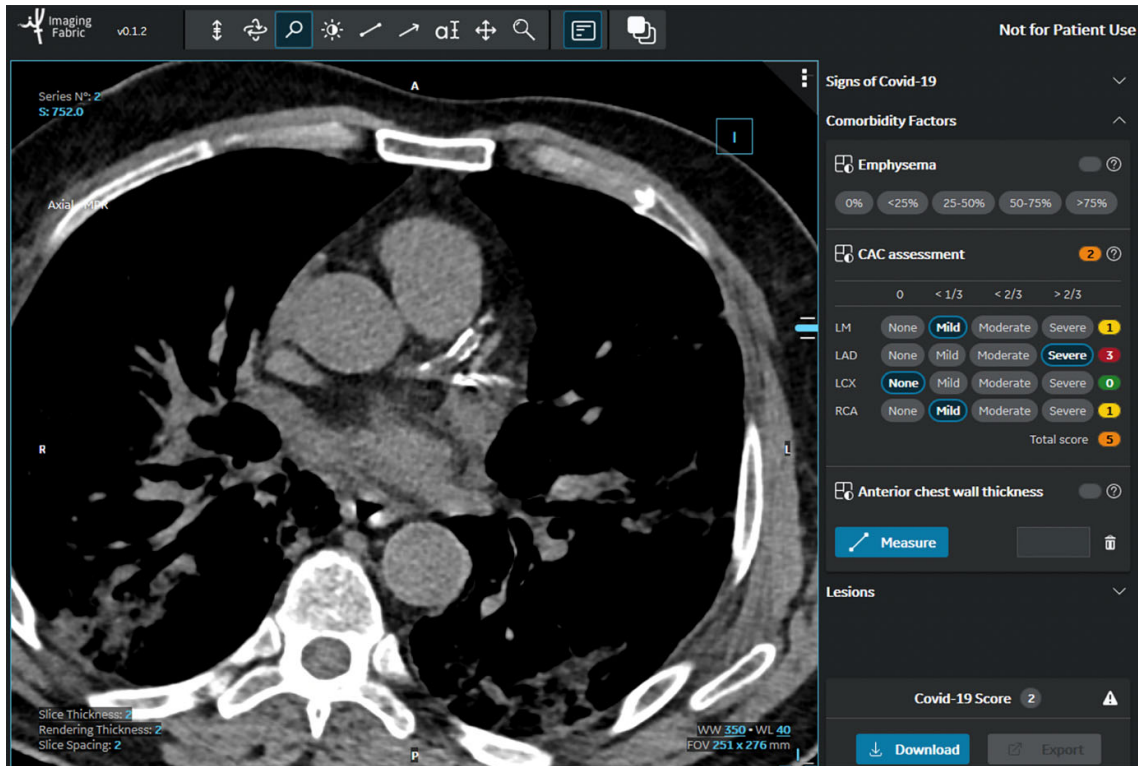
CT annotations: Visual scoring of coronary artery calcifications. The coronary artery calcium score was evaluated according to the method by Shemesh et al. (13). Calcification in each of the four main coronary arteries (LM:left main, LAD:left anterior descending, LCX:circumflex, and RCA:right) was categorized as none, mild, moderate, or severe. Calcification was classified as mild when less than one-third of the length of the entire artery showed calcification, moderate when one-third to two-thirds of the artery showed calcification and severe when more than two-thirds of the artery showed calcification.
